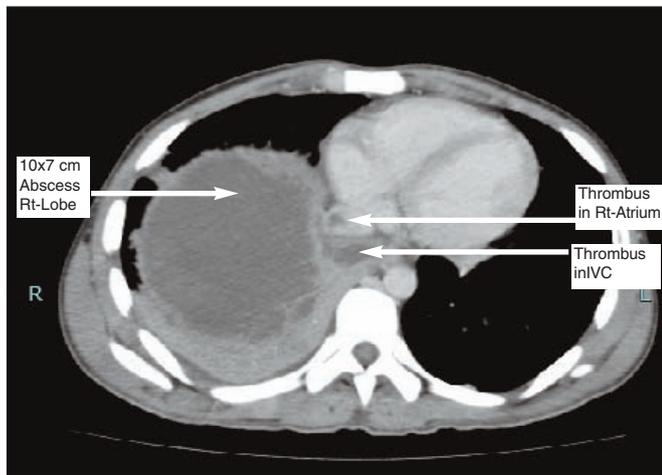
CT scan shows large abscess Tr-lobe of liver with IVC thrombosis wxtending into Rt-atrium.
